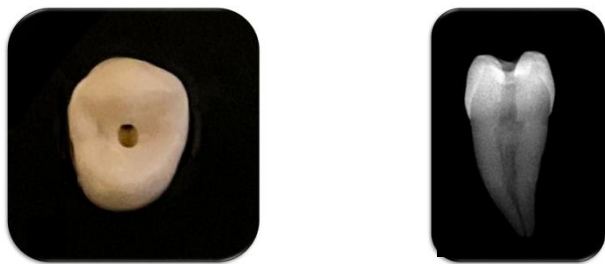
and 2B. Show the conservative access cavity preparation and the corresponding radiograph.
